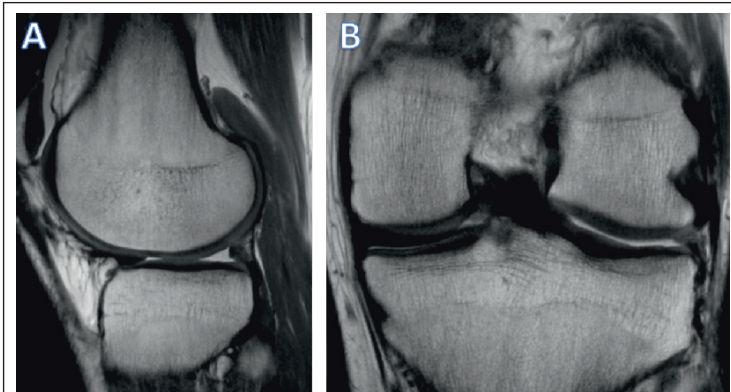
MRI scans of a buckled handle tear of the lateral meniscus. A) Sagittal MRI view of the right knee joint showing degenerative changes on the posterior part of the lateral meniscus; B) Coronal MRI view of the right knee joint showing degenerative changes of the lateral meniscus (on the right).
